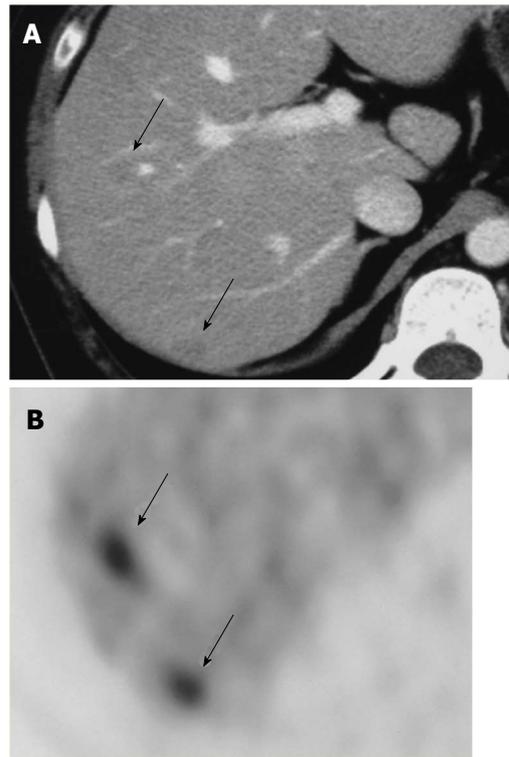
Liver metastases due to cervical cancer; A: CECT shows unclear low density areas in the liver (arrows). B: FDG-PET clearly depicts two liver metastases (arrows).
